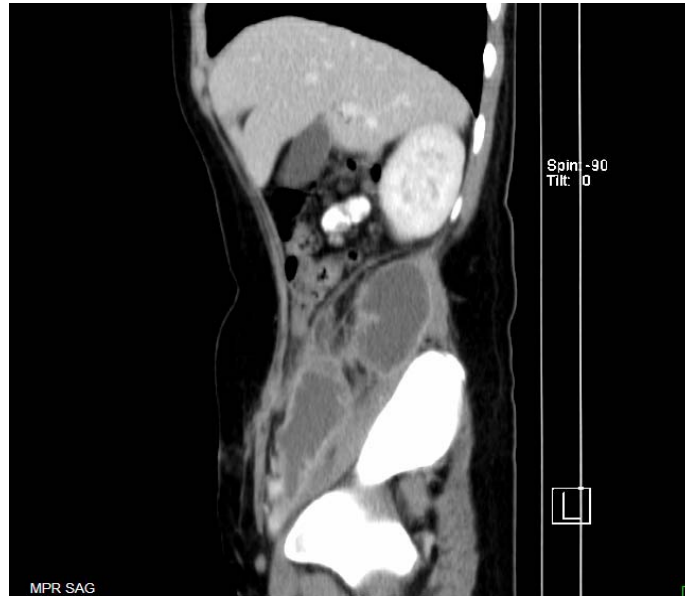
CT scan with contrast, sagittal view, showing a gross loculated retroperitoneal collection in the right flank. The mass comes in contact with the iliopsoas muscle while extending cephalad to the inferior pole of the kidney and caudal to the deep inguinal ring.*
